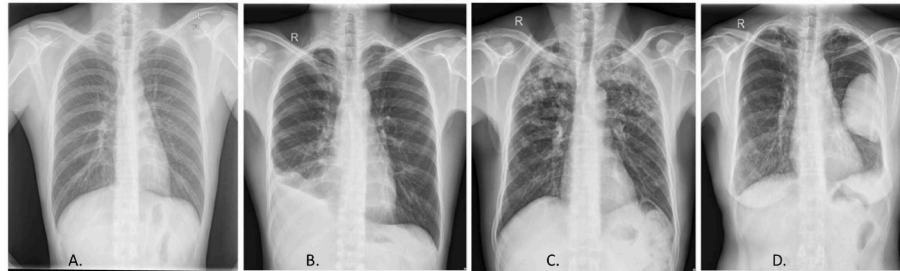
Radiological diagnosis of TB, Chest X-ray. (A) Normal chest X-ray. X-ray displaying different manifestations of TB, (B) pleural effusion, (C) infiltrates, (D) cavity lung lesion. Reprinted from (Ayaz et al., 2021) (open access).
